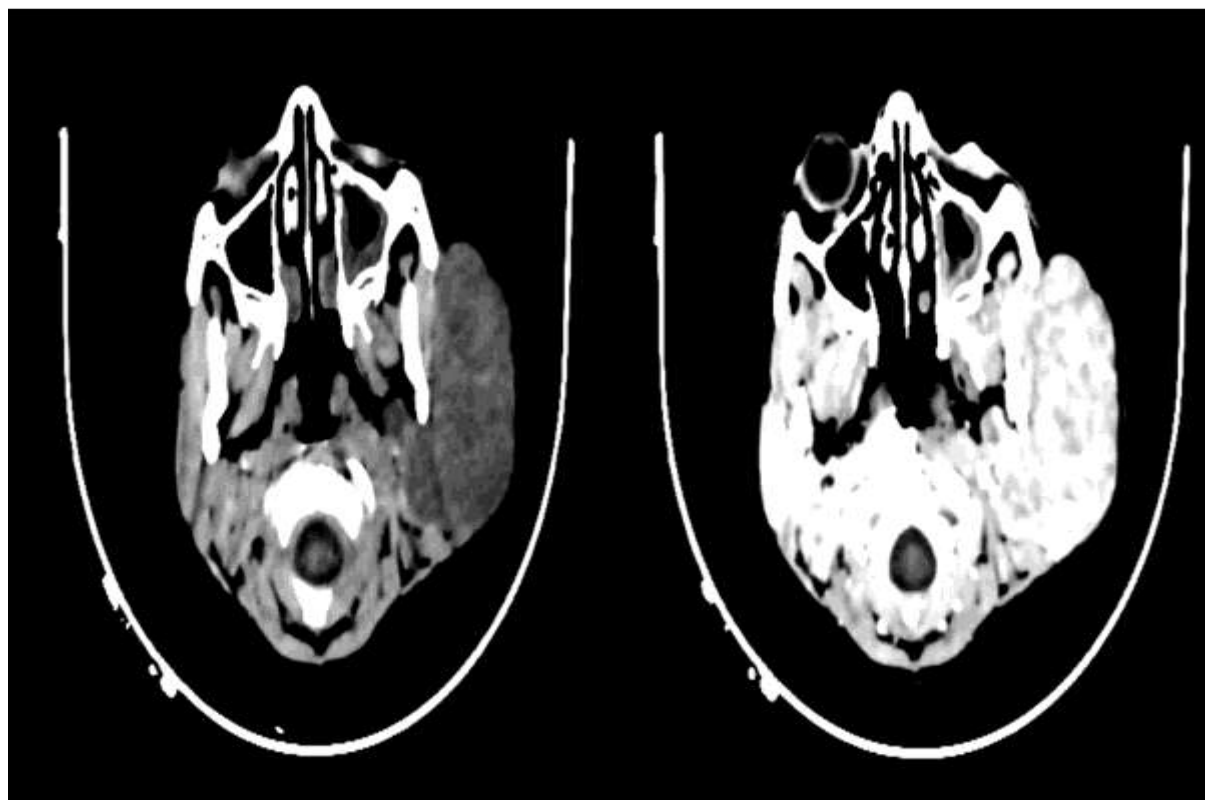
Axial CT images before and after contrast injection showing the mass involving the right parotid gland.
